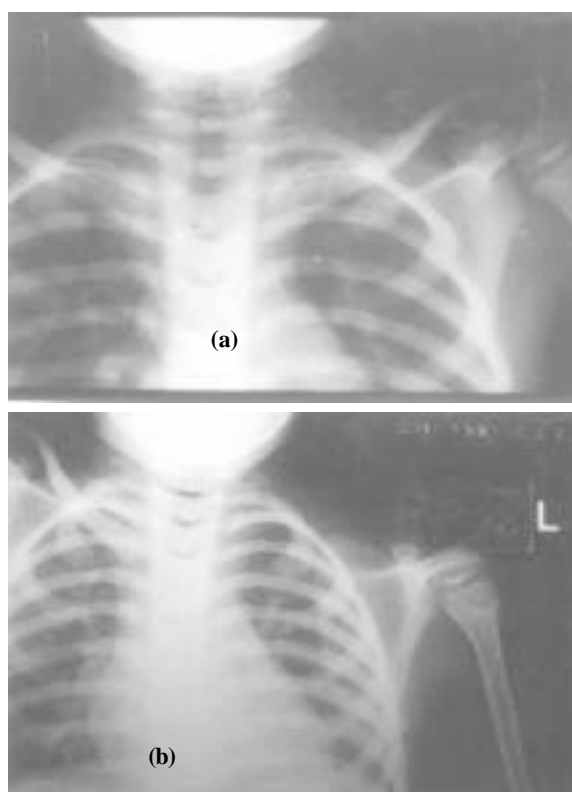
(a) Pre operative radiograph of a case of Ewing's sarcoma (case 8) of the left clavicle - medial 1/3; (b) after type IV resection
